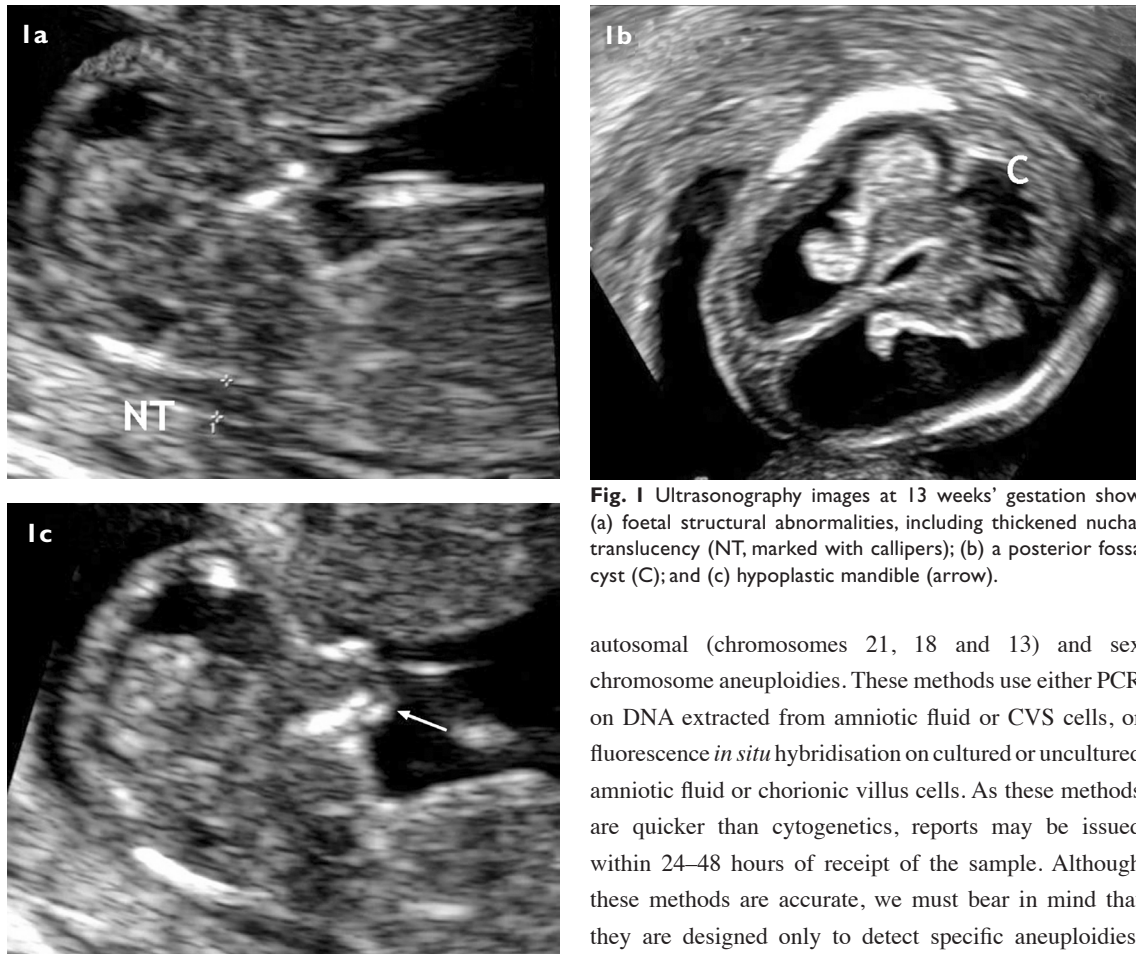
Ultrasonography images at 13 weeks' gestation show (a) foetal structural abnormalities, including thickened nuchal translucency (NT, marked with callipers); (b) a posterior fossa cyst (C); and (c) hypoplastic mandible (arrow).
